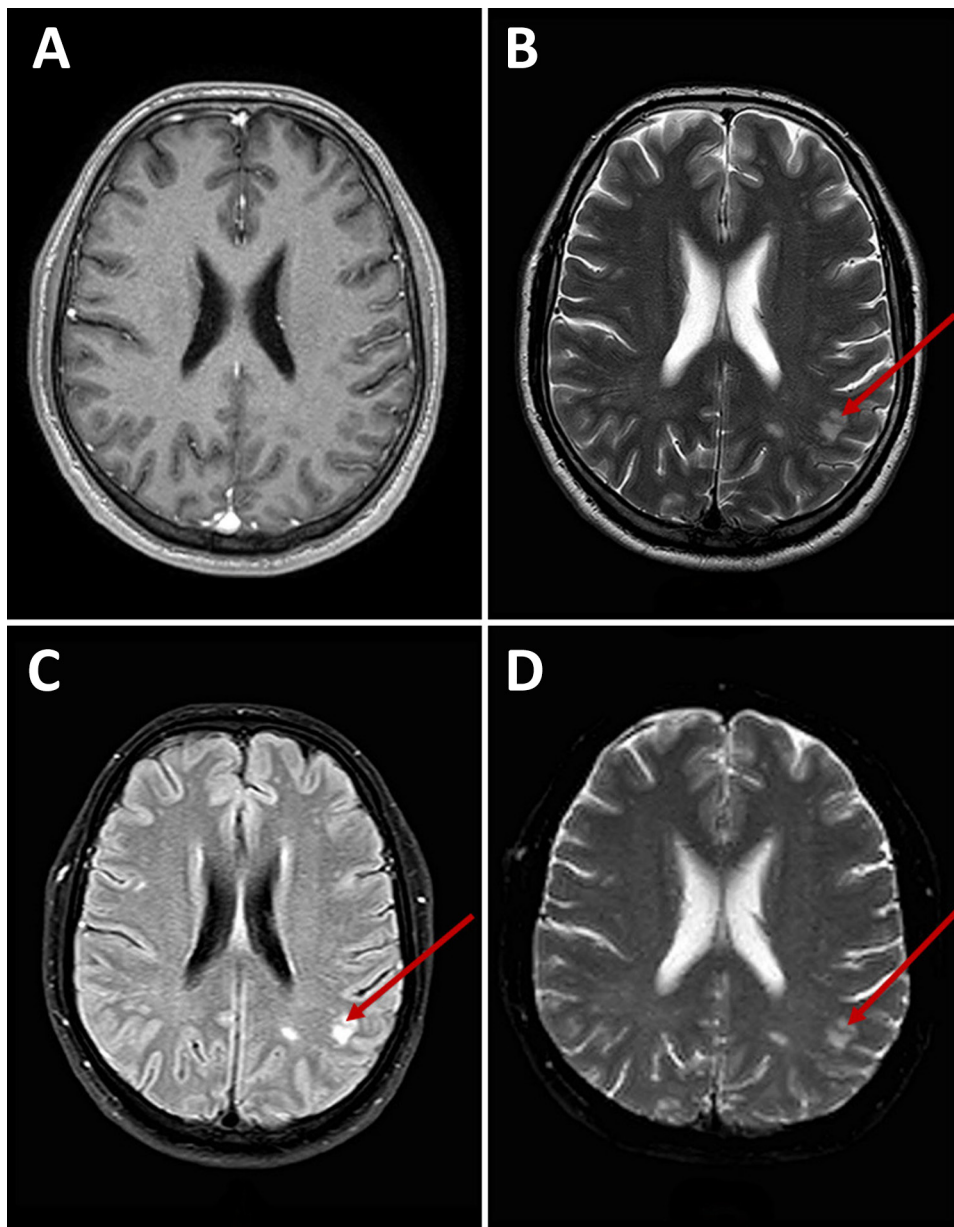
Axial brain magnetic resonance imaging of a patient with *Chlamydia psittaci* meningitis, Chile, 2023. A) T1-weighted image shows unremarkable appearance. B) T2-weighted image; C) fluid-attenuated inversion recovery image; and D) diffusion-weighted image show bilateral white matter hyperintensities (arrows).
